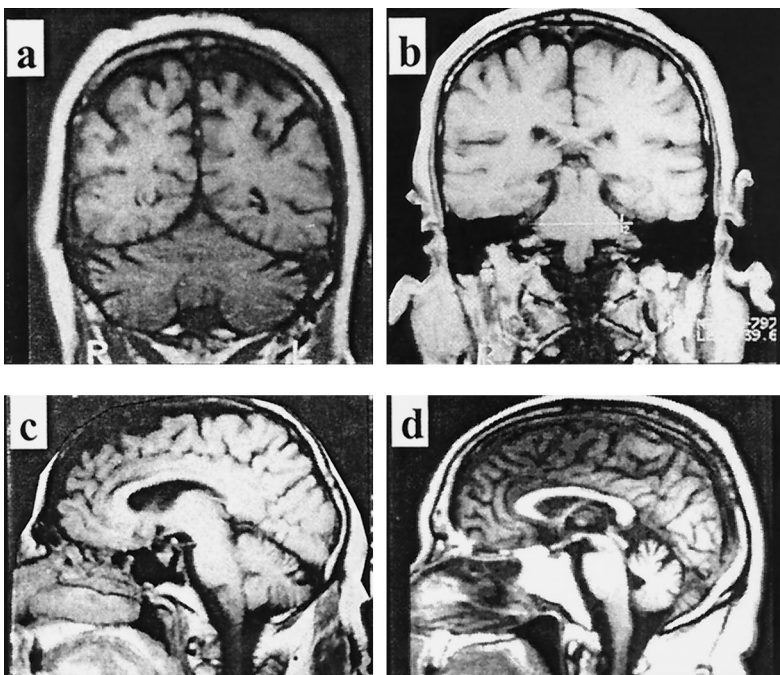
Brain MRI of Patient 1 shows mild atrophy of the cerebellar cortex and mild reduction of the transverse diameter of the basis pontis in coronal views (a and b), and mild atrophy of the cerebellar vermis in a sagittal view (c). Brain MRI of Patient 2 shows mild atrophy of the cerebellar vermis (d). All are T1-weighted images (SE = 460).
